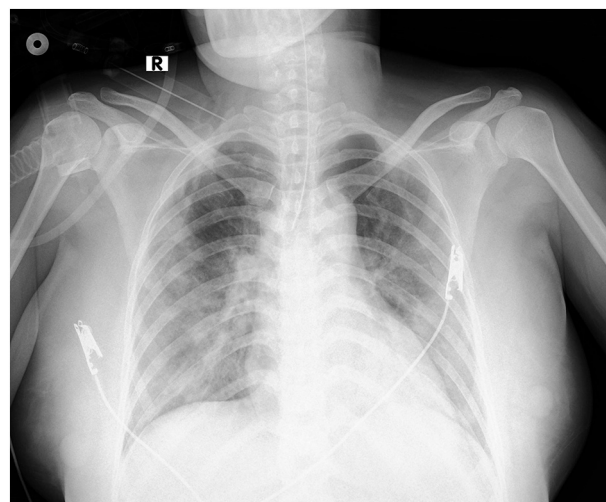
Chest X-ray taken on hospital day 4.
